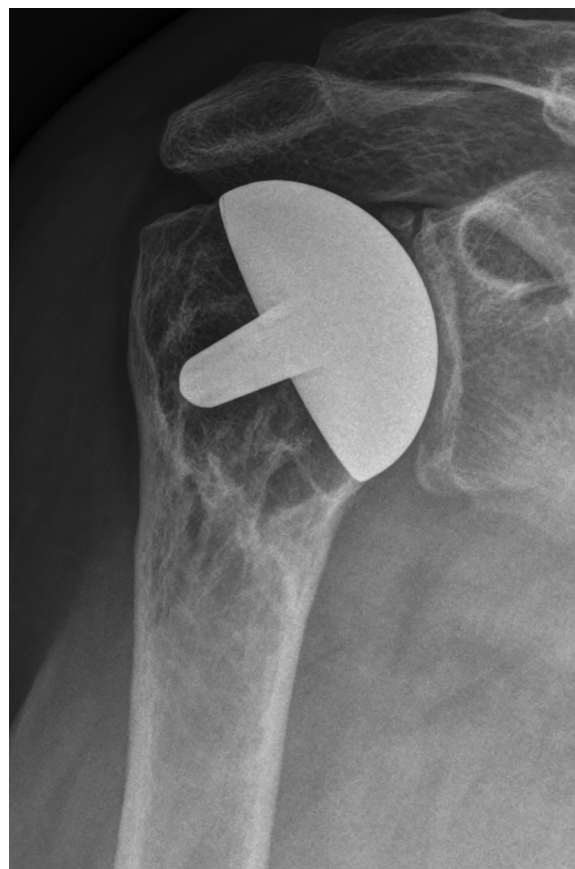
The x-ray 12 years after surgery.
